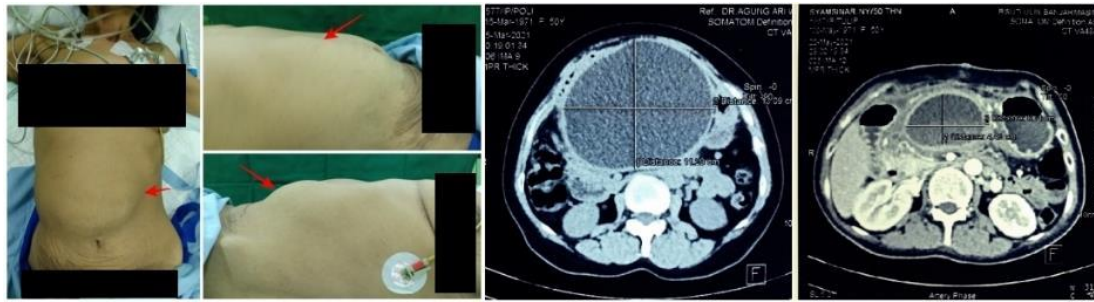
Clinical picture and CT scan before and after the operation of Case 2.
